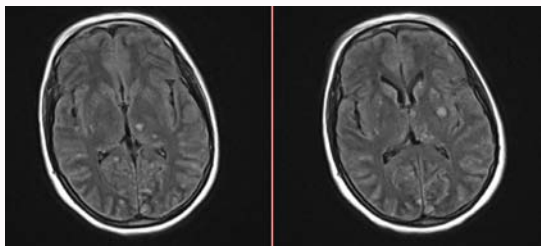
T1 weighted Brain MRI sections showing multiple nodular lesions in different cortical and sub-cortical areas enhancing with gadolinium.
